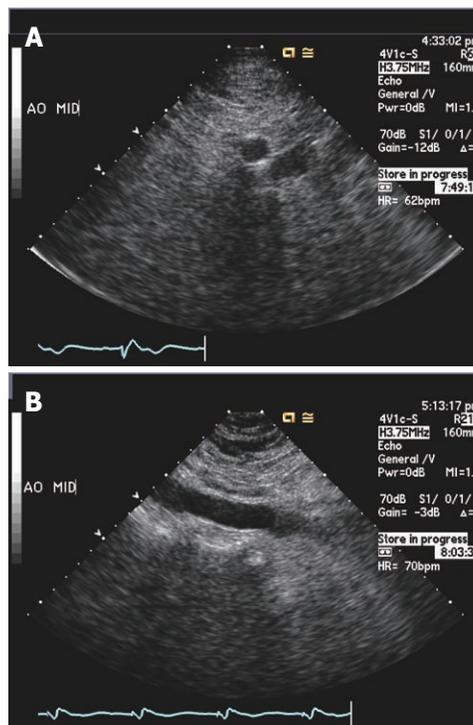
The mid abdominal aorta image obtained during transthoracic echocardiography. A: Transverse image; B: Longitudinal view.
